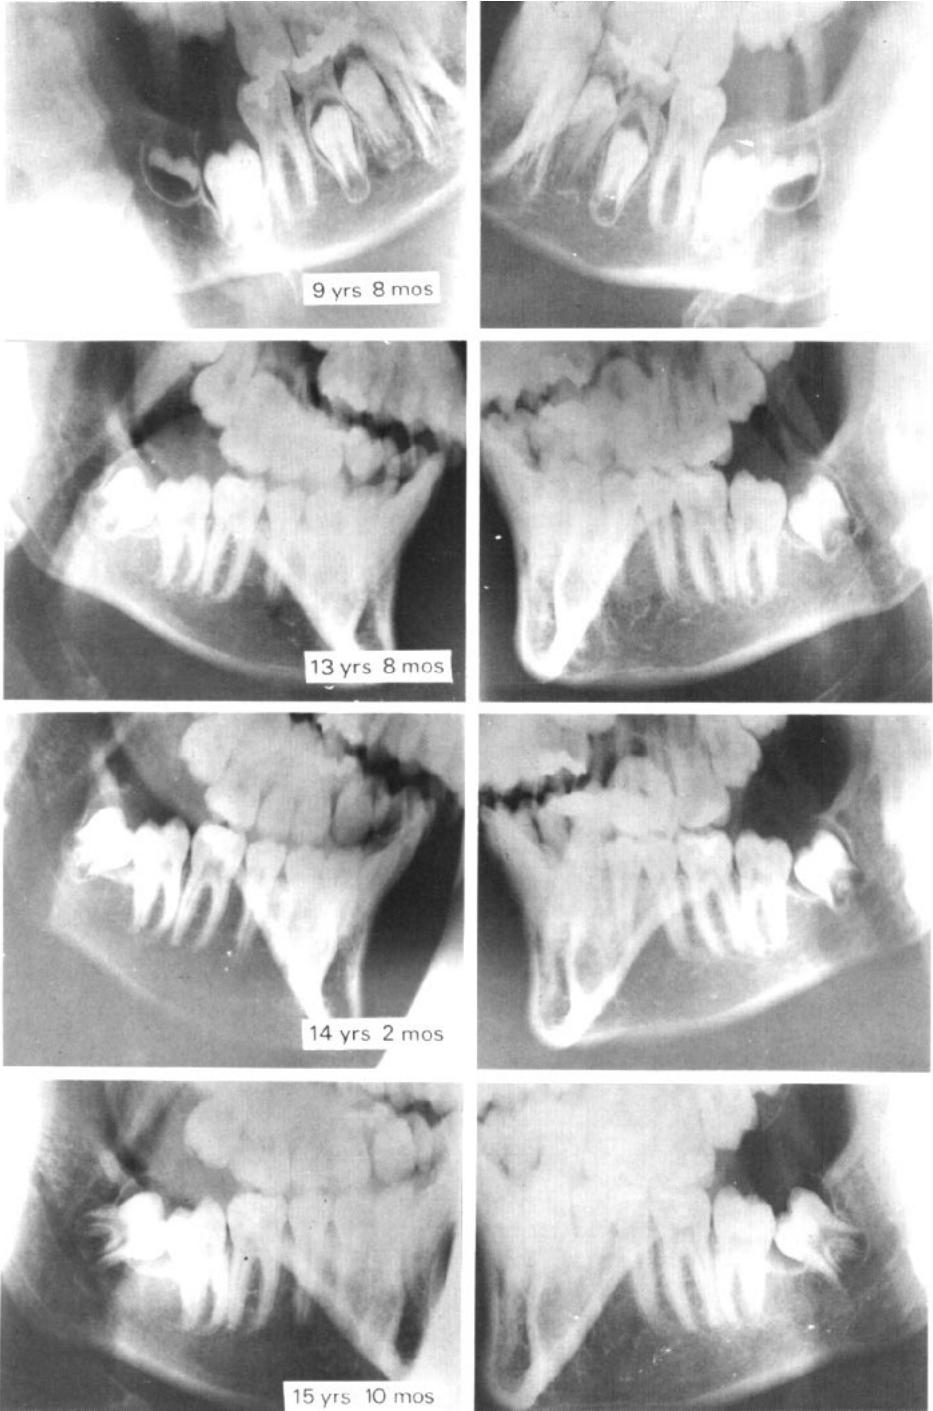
Radiographs taken before, during, and several years after treatment of a nonextraction case which was a severe Class II, Division 1. Growth response was poor. The third molars experienced rotational movements which were the reverse of normal.
